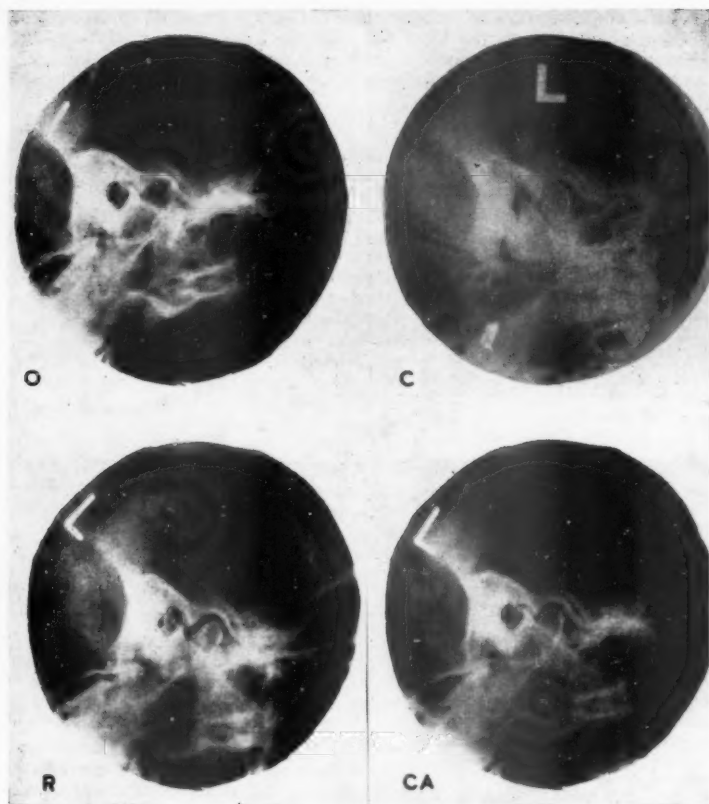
Radiographs of temporomandibular joint before and after correction of backward displacement of the condyle in malocclusion. C, closed. The condyle is retro-positioned in the fossa. O, open. There is limited forward movement of the condyle. R, resting. Compare with C; in normal occlusion the condyle does not move back from the resting position. CA, closed, wearing bite-opening appliance. The condylar position is corrected to that of R.
